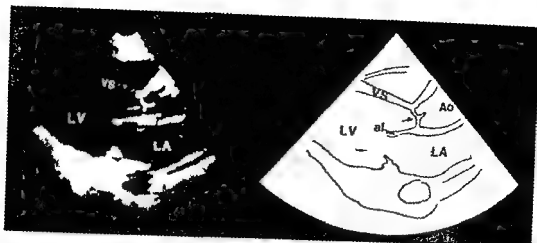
A left ventricular longitudinal cross sectional echocardiogram from a normal control depicting the left ventricle (LV) left atrium (LA) ventricular septum (VS) and the anterior leaflet of the mitral valve (al) The white arrow's head lies at the mouth of the aorta at the level of the aortic ring and points to the coaptation point (at mid aortic level) of the right and posterior aortic valve cusps in diastole The cusps lie well above the aortic ring
